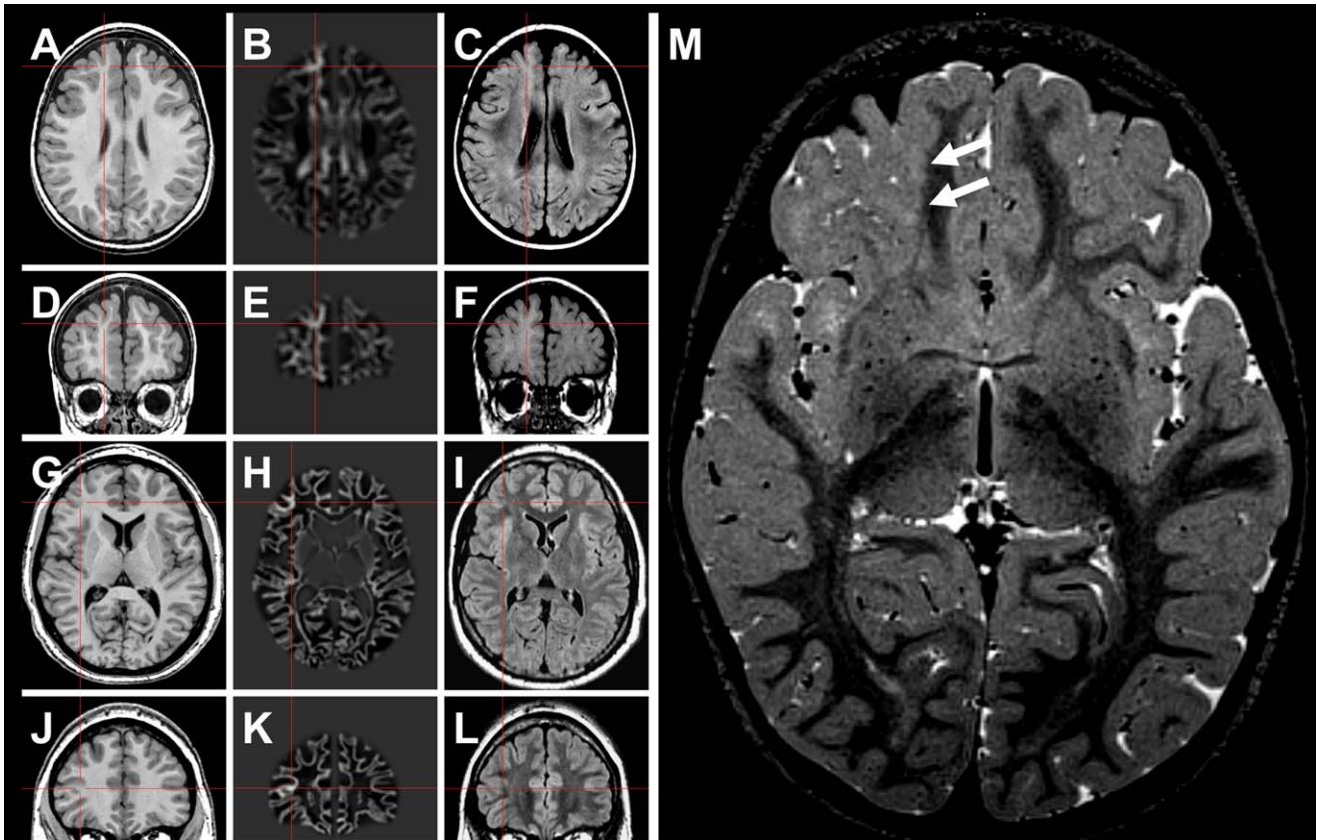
Neuroimaging findings in MOGHE. A–F. Patient #2 (Table 1). G–L. Patient #13 (Table 1). In the latter patient, the lesion became evident only after morphometric MRI analysis (junction image in 2nd column). (23) Red crosses highlight a suspected lesion in T1 (1st column), and postprocessed junction maps (2nd column). 3rd column:
